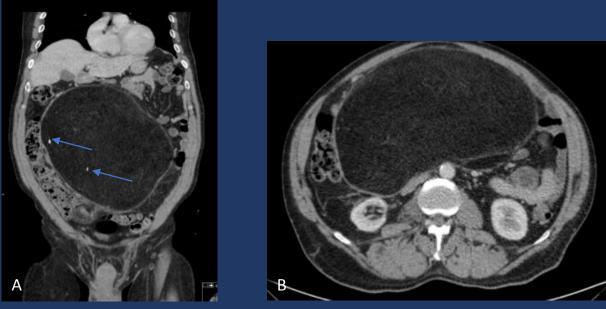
Well-differentiated liposarcoma – Coronal (A) and axial (B) contrast-enhanced CT reconstrutions showing a well-circumscribed mass, predominantly fatty (>75%), with some calcifications (arows). *Source: Radiology department, Centro Hospitalar de São João do Porto, EPE*
